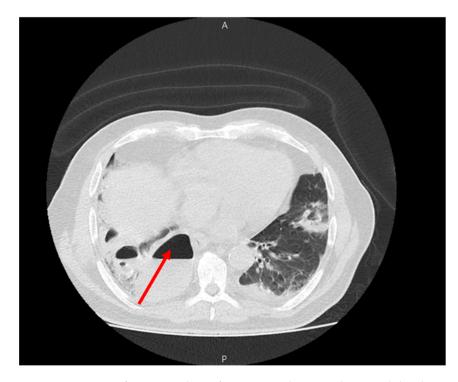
CT scan of patient 5 days after pneumothorax and removal the chest tube. The lack of abscess shrinkage is noticeable (red arrow).
